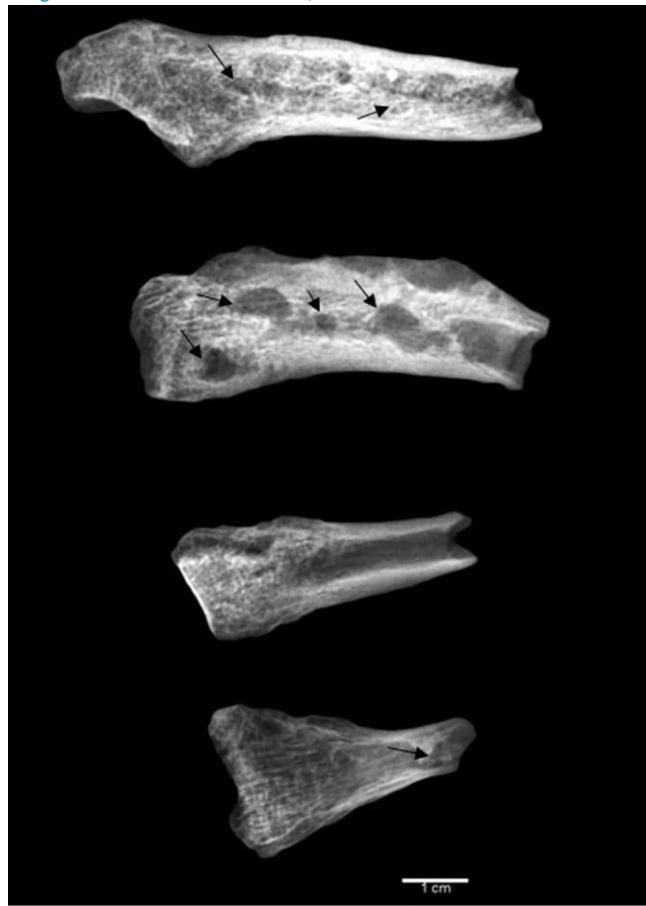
Radiograph of left metatarsals showing multiple round lytic foci (arrows) of similar size.
